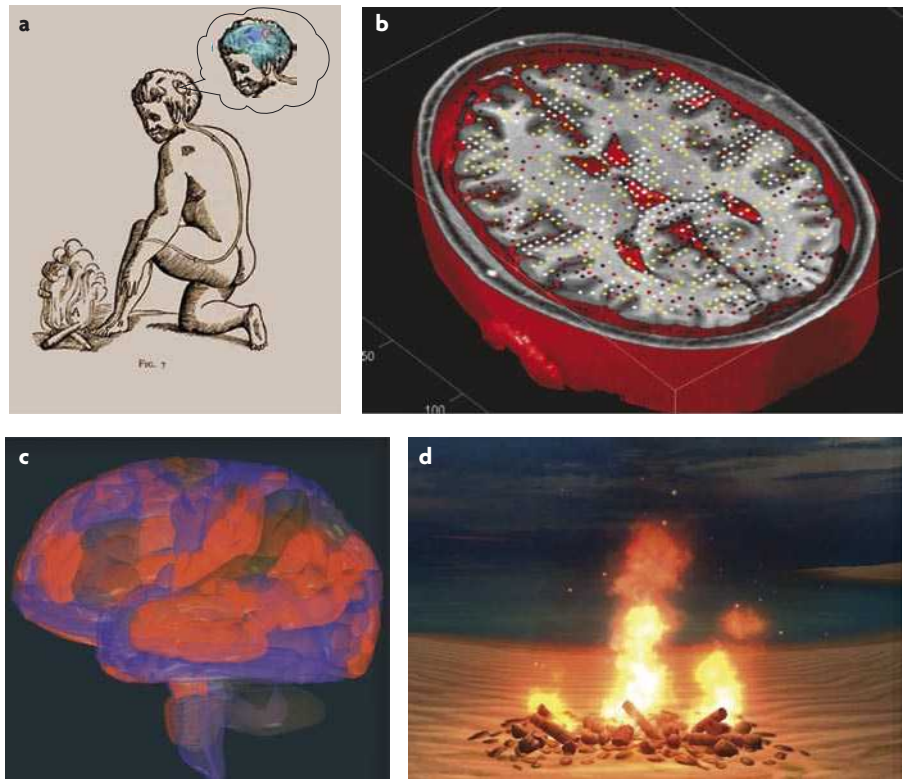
Imaging the human brain in real time. a | Descartes used introspection as a way to perceive the mechanisms of the mind. This approach to observing the mind–brain interface is what people were limited to in the absence of technology. b | Today, using real-time functional MRI, it is possible to measure the level of activation from $\sim 2^{16}$ brain locations per second. Here, measured activation levels are represented as colours that have been overlaid onto a three-dimensional rendered set of anatomical brain images. c | Information from individual spatial points can be segregated into multiple anatomically defined three-dimensional regions of interest. Here the activation levels (represented as colours) of three brain regions are rendered on a translucent 'glass brain' view. d | Activation in these regions can either be plotted second-by-second in real time or can be presented to subjects in more abstract forms, such as this virtual-reality video display of a beach bonfire, in which each of the three elements of the flickering fire corresponds to activation in a particular brain region. Brain activation can control arbitrarily complex elements of computer-generated scenarios.
